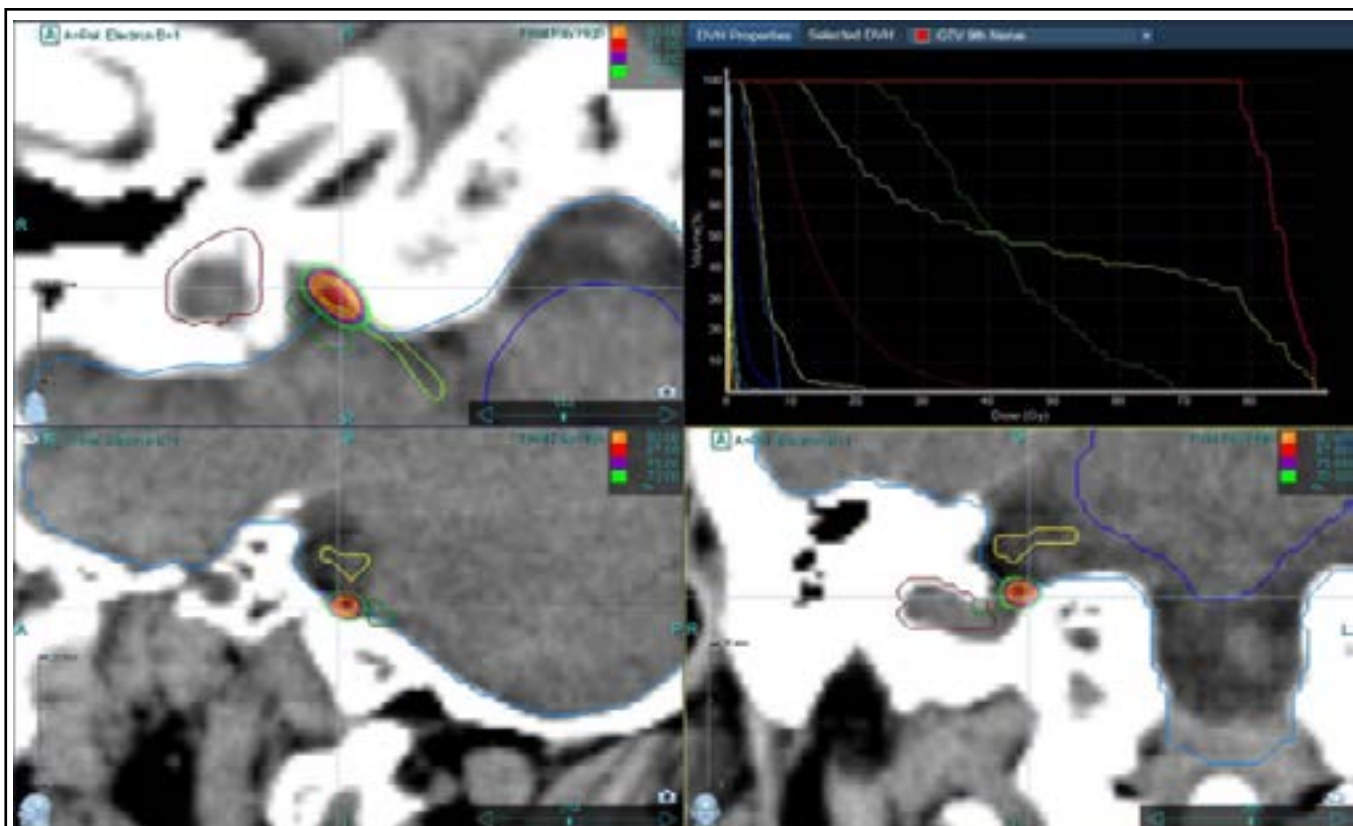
Upper left: Proximity of the target volume (Right glossopharyngeal meatus) depicted in bright red and the avoidance structure (vagus nerve) close to brainstem (dark blue). Upper right, Dose Volume histogram showing target volume coverage. Lower left and right: Sagittal and coronal CT images of target volume.
